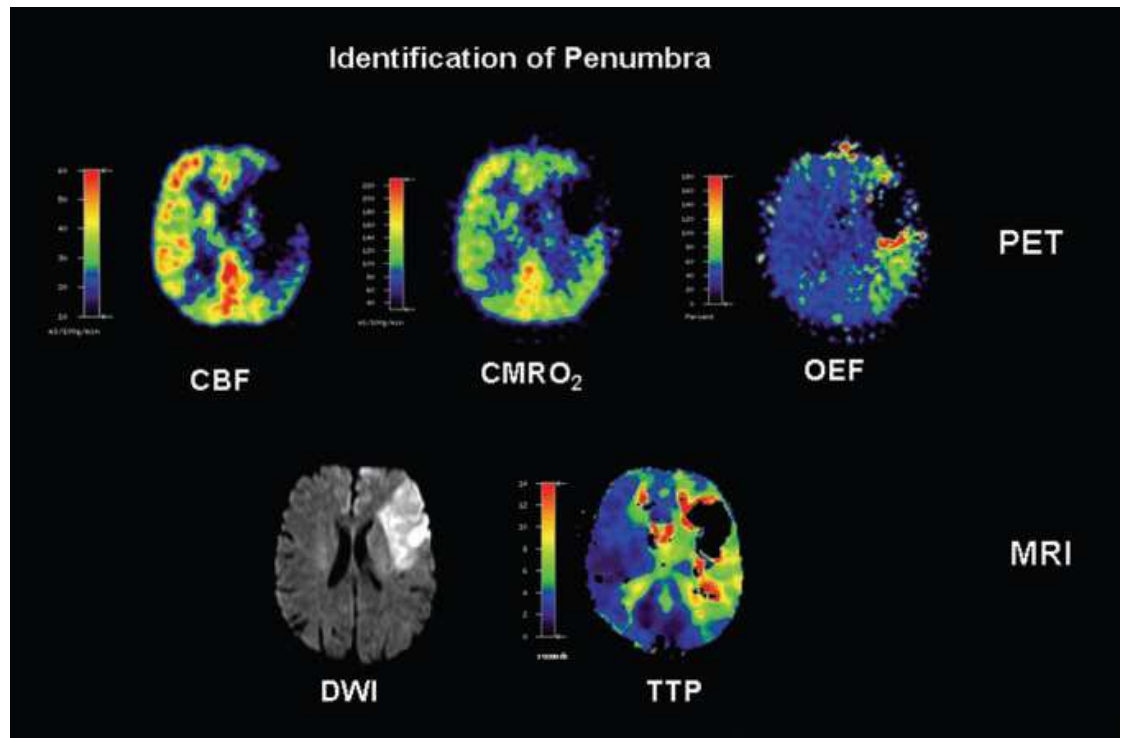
Multimodal imaging 5 hours post-stroke in a human patient. Penumbra is defined as a region with reduced CBF, preserved CMRO_2 and increased OEF, which correlates approximately with MRI findings (DWI hyperintensity and time to peak (TTP) delay of 4 seconds). Adapted from Heiss et al (2004)
